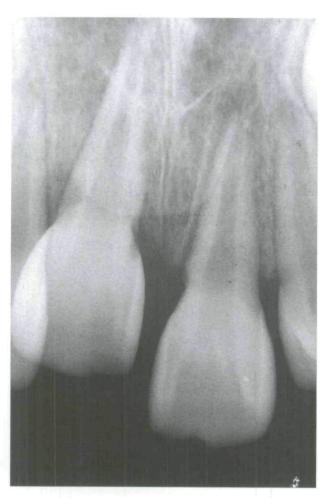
Radiograph of the right permanent central incisor, with completely closed apices.
